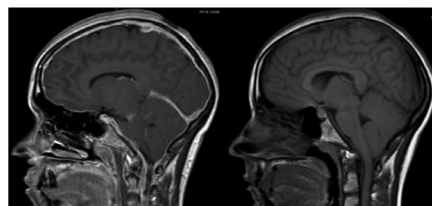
MRI: a. Meningeal enhancement after gadolinium administration. b. Cerebellar tonsils descent.
